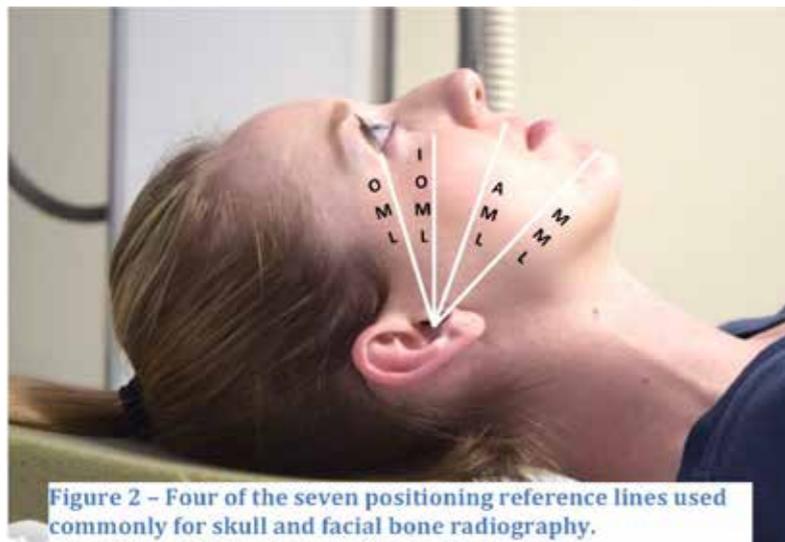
Four of the seven positioning reference lines used commonly for skull and facial bone radiography.
